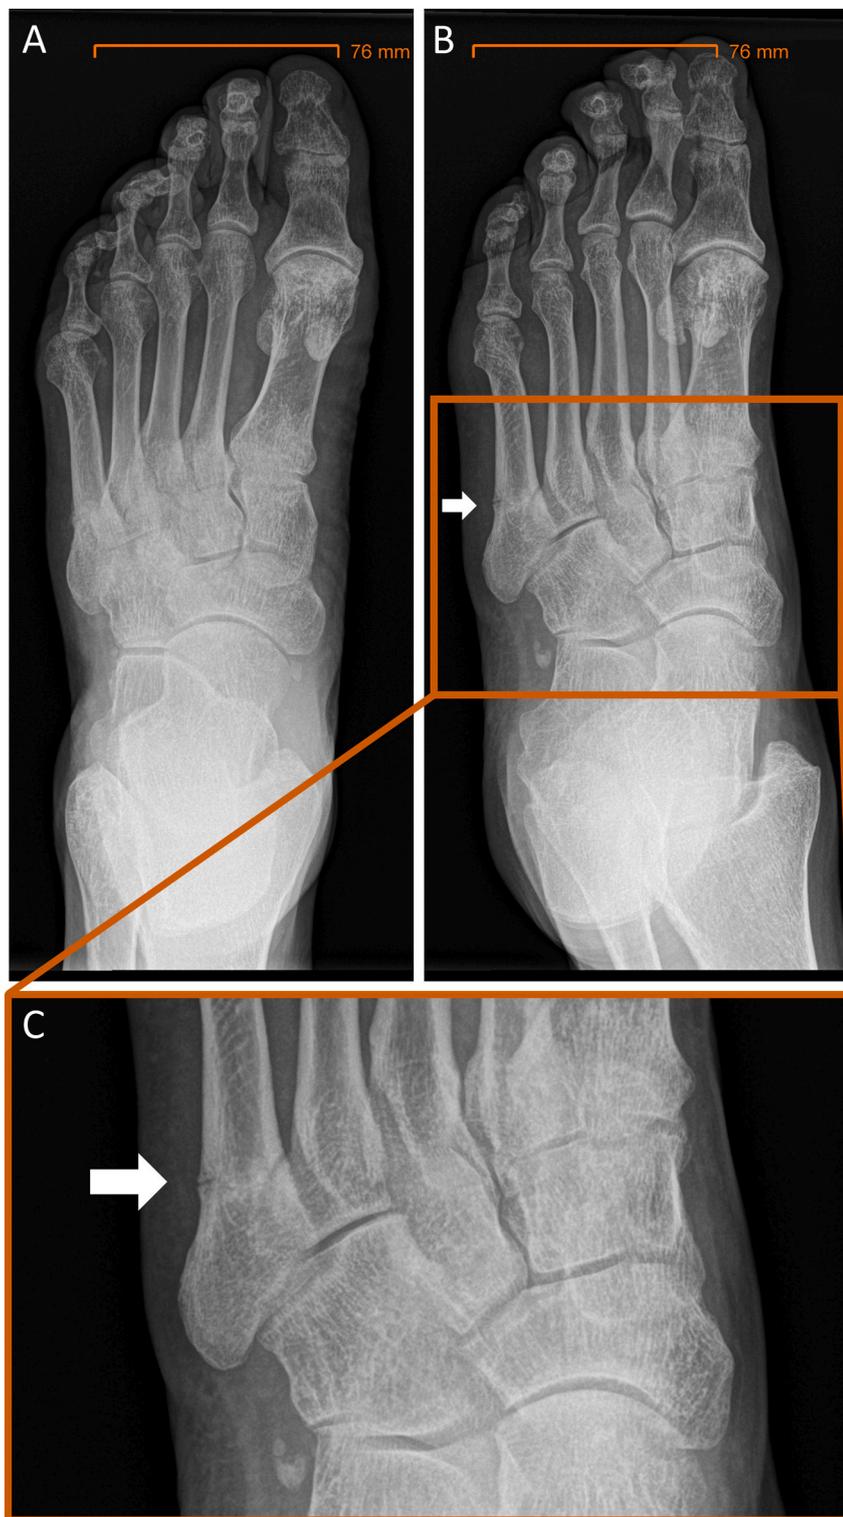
Atypical proximal fracture of the left fifth metatarsal bone (Looser zone indicated by the white arrow) which becomes clearly visible only after rotation of the foot. The patient presented with pain and was unable to walk after repeated infusions of ferric carboxymaltose. At the time of presentation the patient was hypophosphatemic and presented with osteomalacia as shown by conventional x-ray of the foot. (A) Dorsoplantar x-ray. (B) Oblique x-ray axis. (C) Enlargement of (B).
